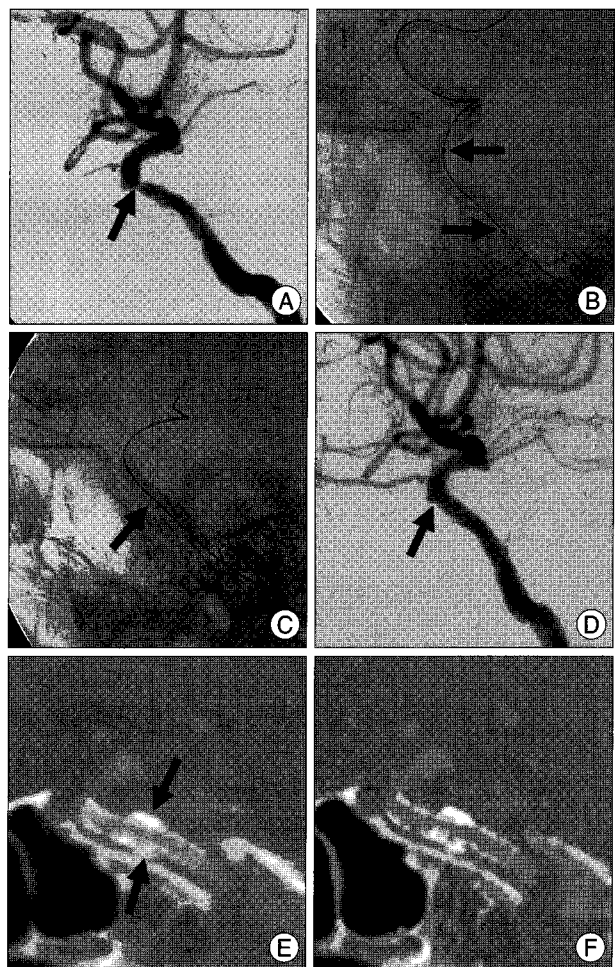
A 55-year-old male presented with dysarthria, dizziness, and gait disturbance. A : Lateral view of the right VA angiogram shows focal severe stenosis (arrow, about 80%) proximal to the PICA (Posterior Inferior Cerebellar Artery) origin of right VA. B : Anteroposterior radiographs show the stent (arrow) during deployment in the stenotic segment of right VA. The used stent is a 4.0/16 mm-sized, balloon-mounted coronary stent (Flexmaster, JoMed, Rangendingen, Germany). C : Immediate postprocedural lateral view of the right VA angiogram reveals nearly normalized diameter of the diseased vessel (arrow). D : After 6 months, follow-up lateral angiogram shows no in-stent restenosis. E : Computed tomography angiography with 16 MSCT is performed at 24 hours after follow-up angiography. Curved axial multiplanar reconstruction with standard sharp kernel (H31f) shows about 47% lumen visibility on the right intracranial vertebral artery. F : Curved axial multiplanar reconstruction with optimized sharp kernel (H60f) shows about 71% lumen visibility on the right intracranial vertebral artery.
